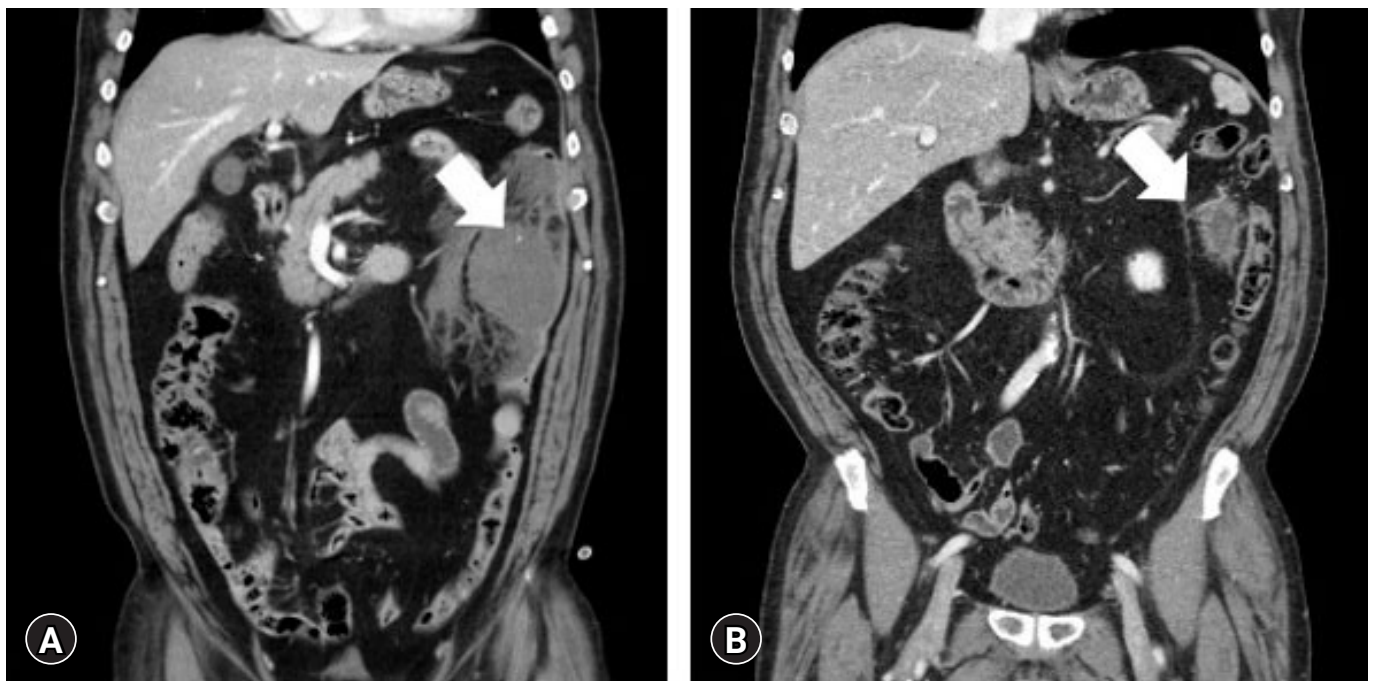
Computed tomography scan performed (A) 2 hours and (B) 7 weeks posttrauma. (A) Extravasation (arrow) and a hematoma in the descending mesocolon. (B) A small amount of hematoma in the descending mesocolon (arrow).
